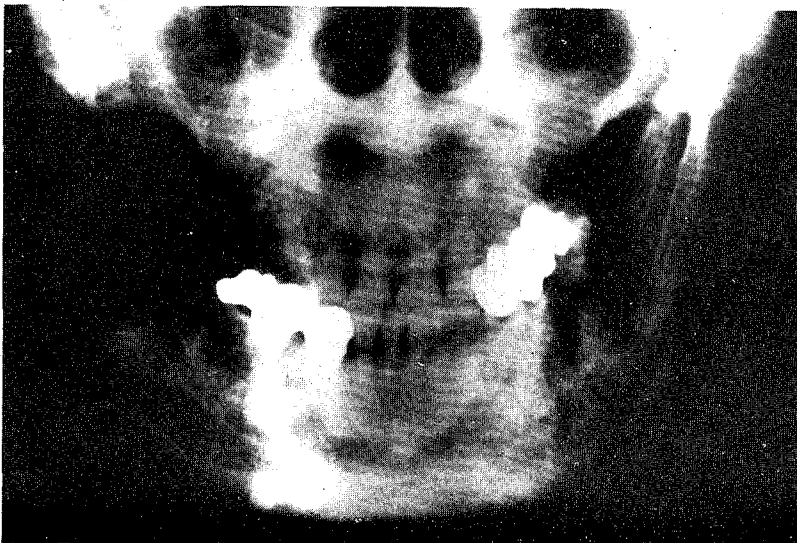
Posteroanterior radiograph showing osseous destruction of ramus of the right mandible.
